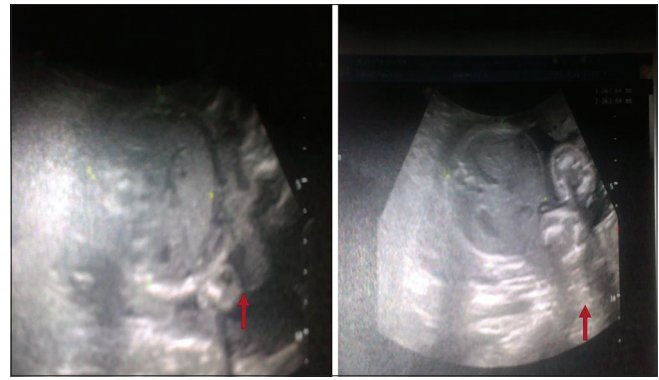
Sonographic appearance of placenta previa
